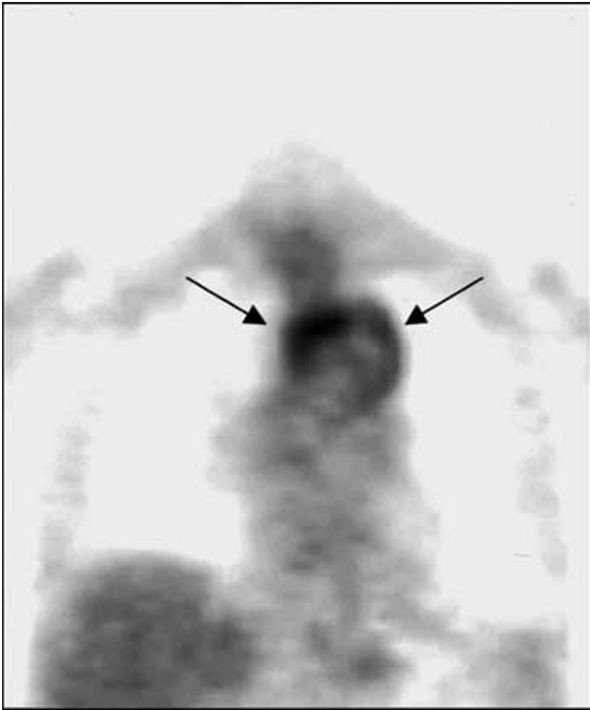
FDG-PET. Transmission-corrected coronal FDG-PET section of the chest at the level of the aortic arch, recorded 1 h after injection of 220 MBq of FDG. The arrows indicate FDG accumulation in the region of the aortic arch.
